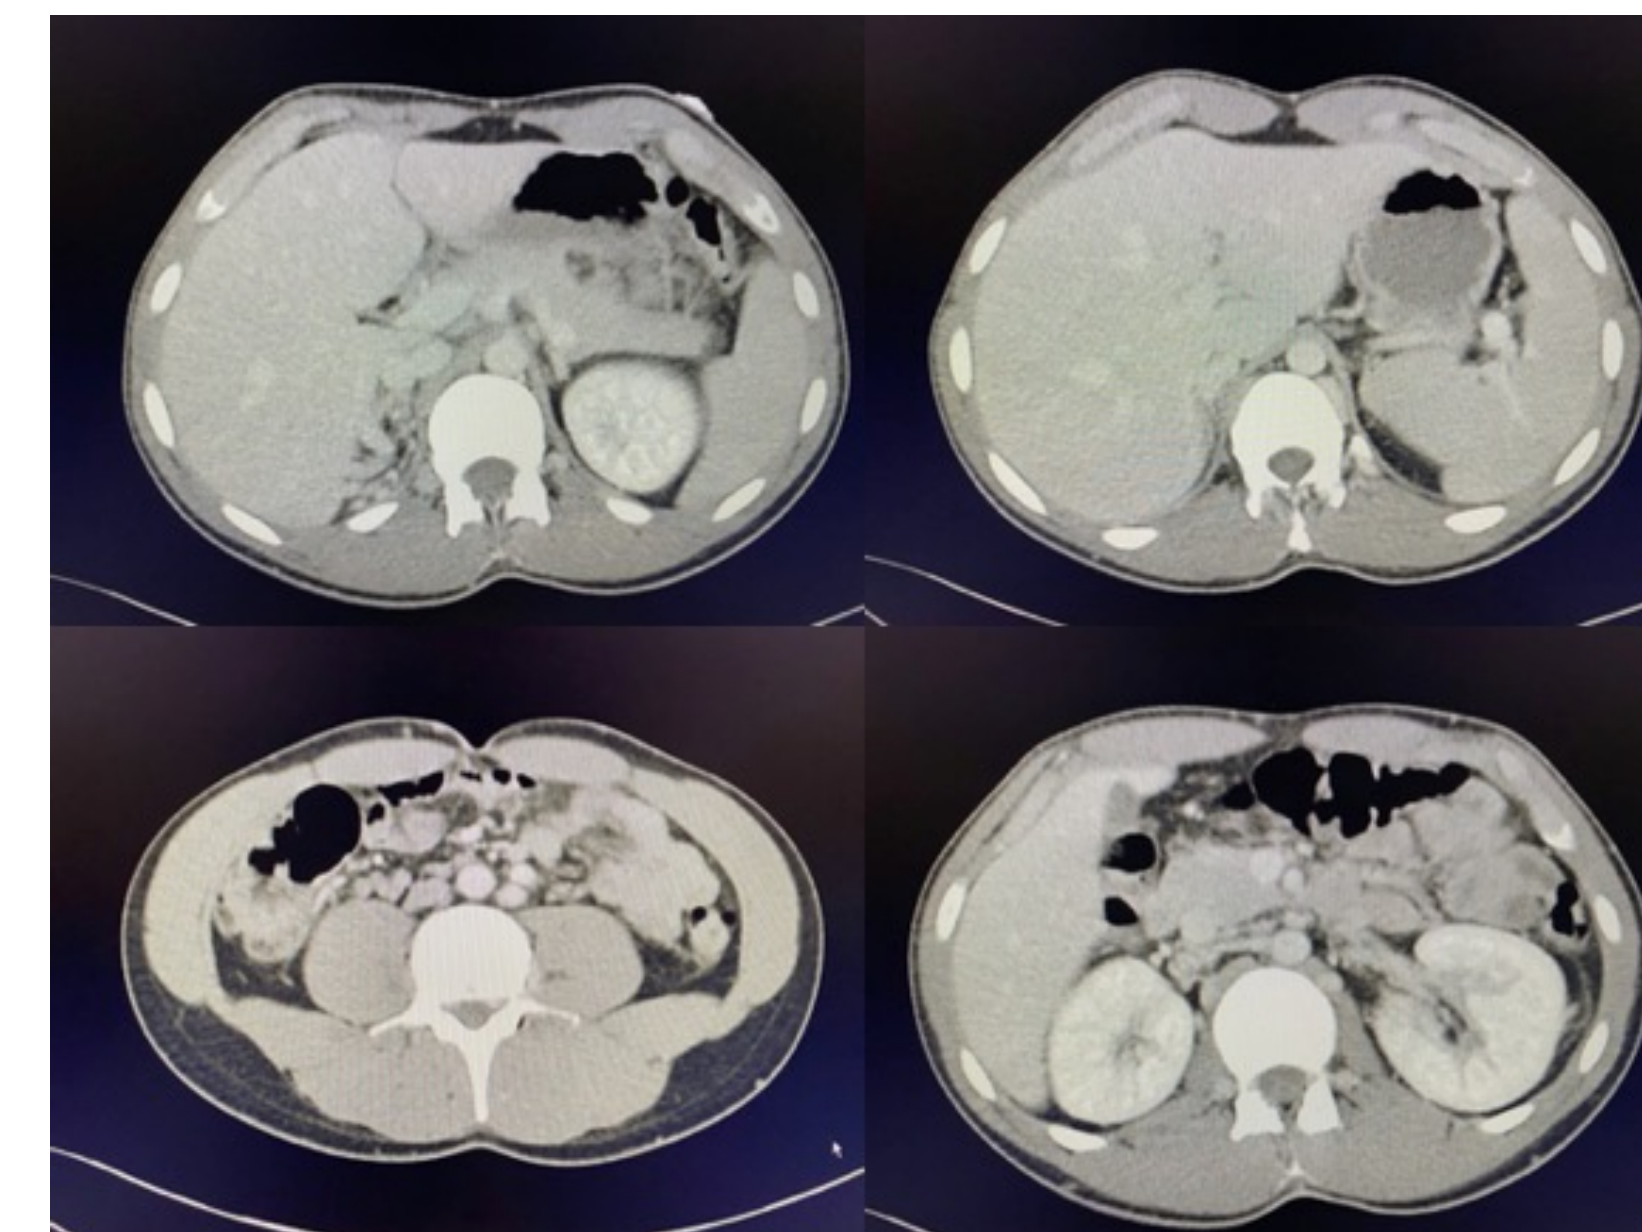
Axial view of the abdomen from the CT venogram. In this image, it is clear there is no visible suprarenal inferior vena cava, however, the abdominal aorta and the infrarenal inferior vena cava are visible.
